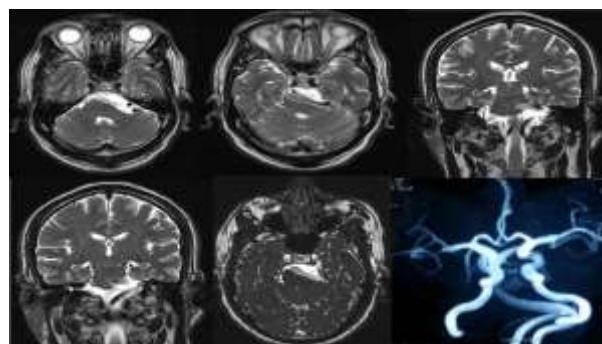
MRI brain with Angio: Bilateral vertebral arteries are dilated and elongated forming basilar arteries on left side. Basilar artery is also dilated and during its course it is significantly compressing the brain stem
